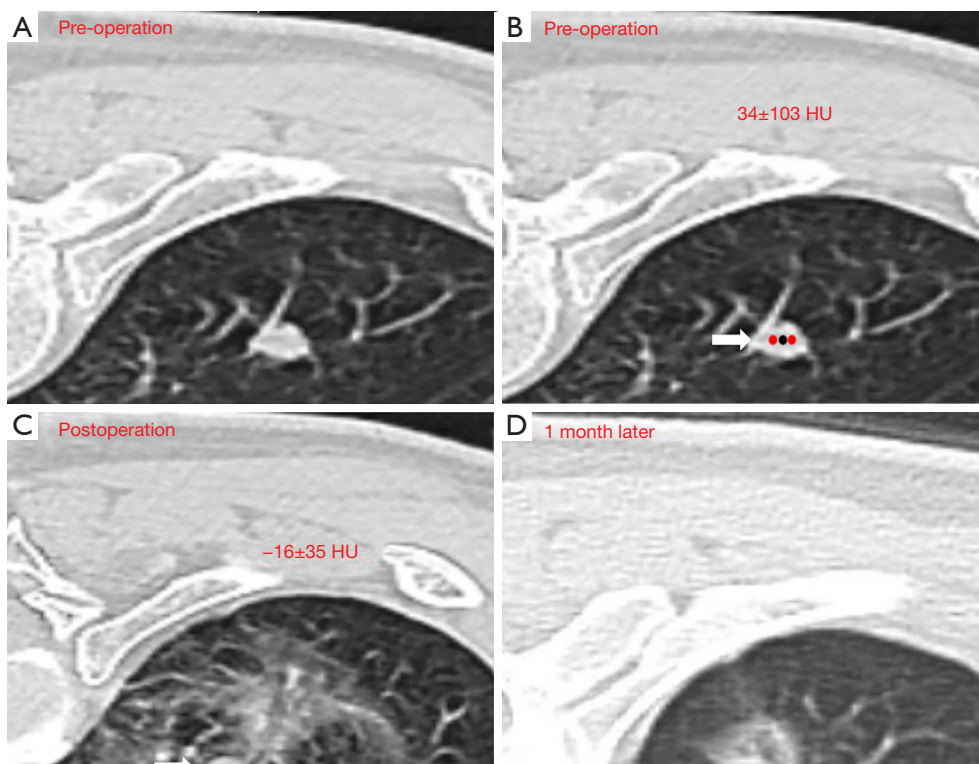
A 60-year-old male patient with lung metastasis of sigmoid carcinoma: (A) a solid nodule 0.9 cm × 0.9 cm × 1.0 cm was seen in middle lobe of right lung; (B) the average CT value at the measurement points before ablation was 34 ± 103 HU; (C) the average CT value at the measurement points after ablation was -16 ± 35 HU; (D) CT reexamination 1 month after surgery showed that the ablation lesion was fibrous strips. The red dots represent the tumor center, while the black dot on either side indicates CT value measurements in (B). The arrow indicates the focal area of the tumor. HU, Hounsfield unit; CT, computed tomography.
